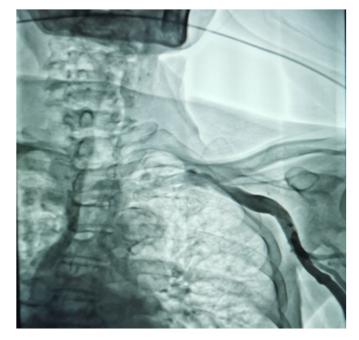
The radiography of axillary vein.
